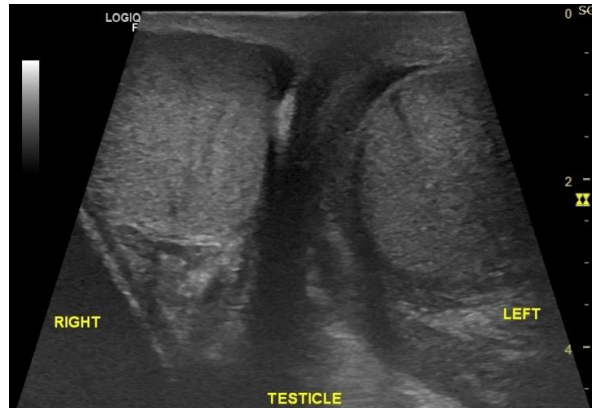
Ultrasound image of scrotal sac. Both the testes are normal in outline and echo texture. No calcification is seen in any of the testis.
